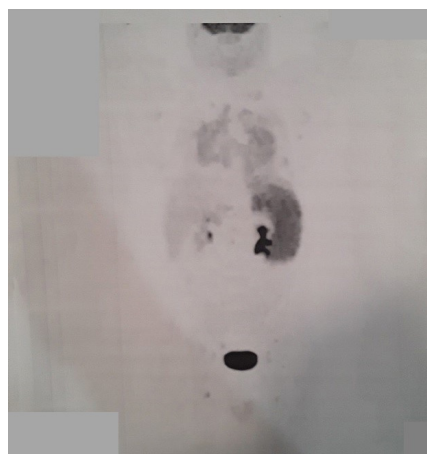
PET/CT scan with 18F-FDG (positron emission tomography/computerized tomography scan with 18F-fluorodeoxyglucose). Multifocal FDG avid reticulonodular changes throughout the lungs, numerous FDG avid enlarged thoracic lymph nodes, enlarged spleen with diffuse increased FDG uptake, several FDG avid abdominopelvic lymph nodes, and several small FDG avid subcutaneous lesions. Few calcified stones were detected in the left kidney and proximal ureter.
